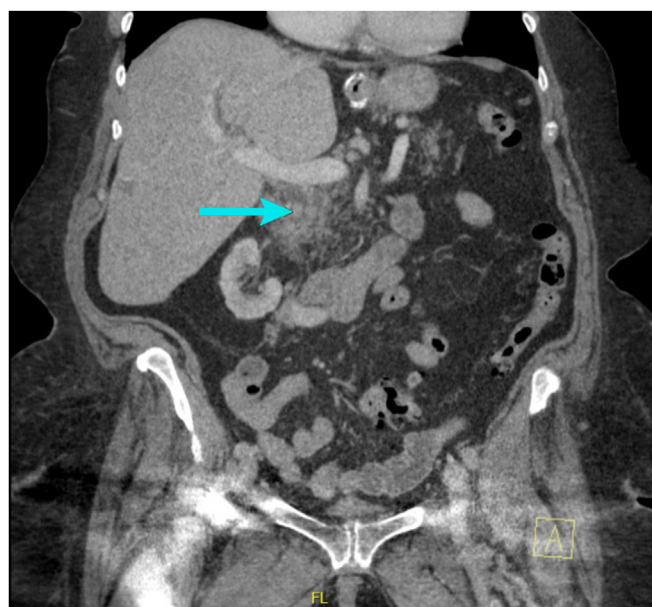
CT of abdomen and pelvis showing evidence of distal common bile duct obstruction (cyan arrow).
